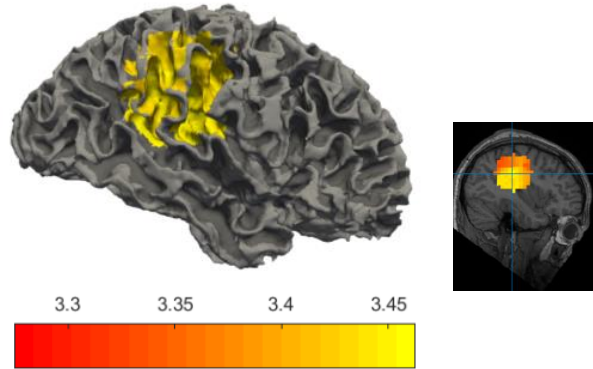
Source localisation for Patient P072 using Solution 1, 2, 3, 4 and validations. (a) Solution 1 and (c) Solution 3 with kurtosis value 3.93 localized to right occipital lobe. (b) Solution 2 was localized to the right premotor cortex, which is concordant with the surgical resection and the onset of the clinical localisation. (d) Solution 4 was localized to right occipital lobe, while it also localized to the left occipital lobe. In the figure of Solution 4, A represents anterior and P represents posterior. The subfigures of (a), (b), (c) and (d) show the corresponding sources registered onto the MRI images. In the colour maps shown in (a), (b) and (c), yellow represents the highest kurtosis value and red represents the lowest values. (e) The validations used in this study, in which surgically resected areas are indicated by the blue surface and pink discs indicate the clinically localized results. In clinical localisation, the onset of source located at right premotor cortex, then propagate to frontal pole. The clinical onset and propagation are shown by the pink discs with number 1 and 2, respectively, in (e).
